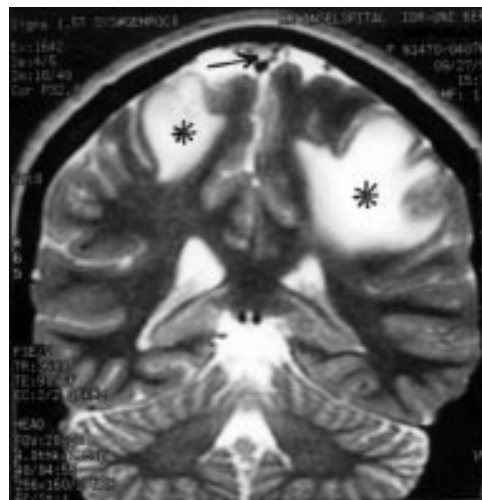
MRI one week after diagnosis of venous thrombosis. The coronal T2 weighted image shows multiple hyperintense infarction areas (*). There is only minimal flow (hypointense area) in the superior sagittal sinus (arrow).
